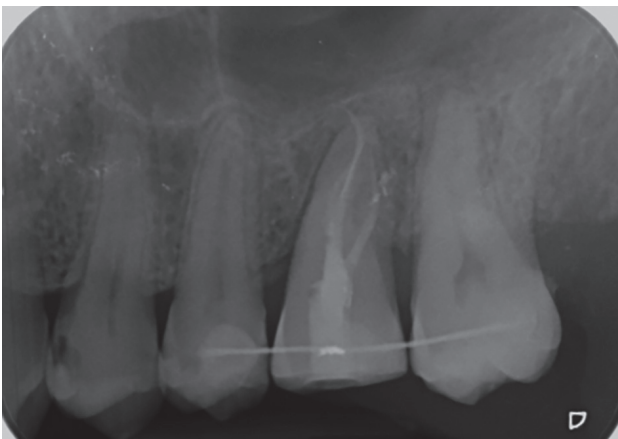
Periapical radiograph after 2 months of the autotransplant.
